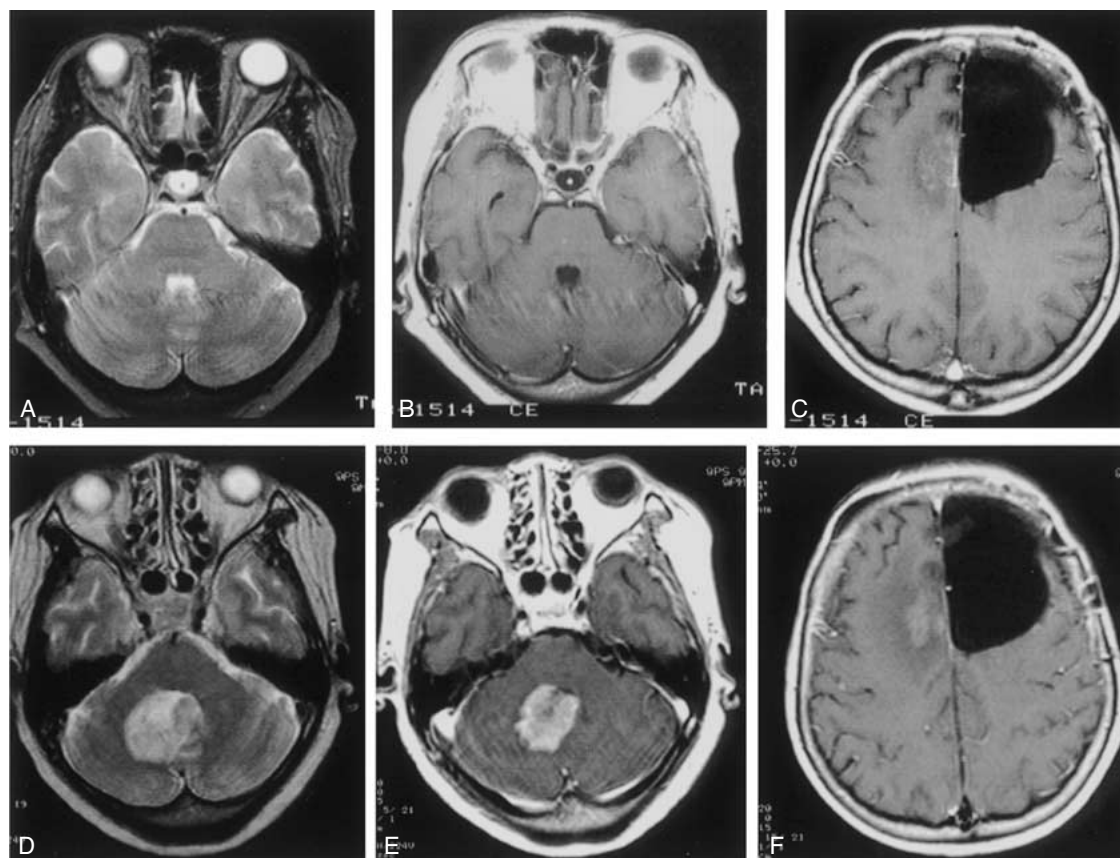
Case 3. T2-weighted (A, D) and T1-weighted MR images with Gd-DTPA (B, C, E, F). The CSF seeding was not evident around the fourth ventricle 1 month after presentation with intractable vomiting (A–C), but appeared 1 month later (D–F).
